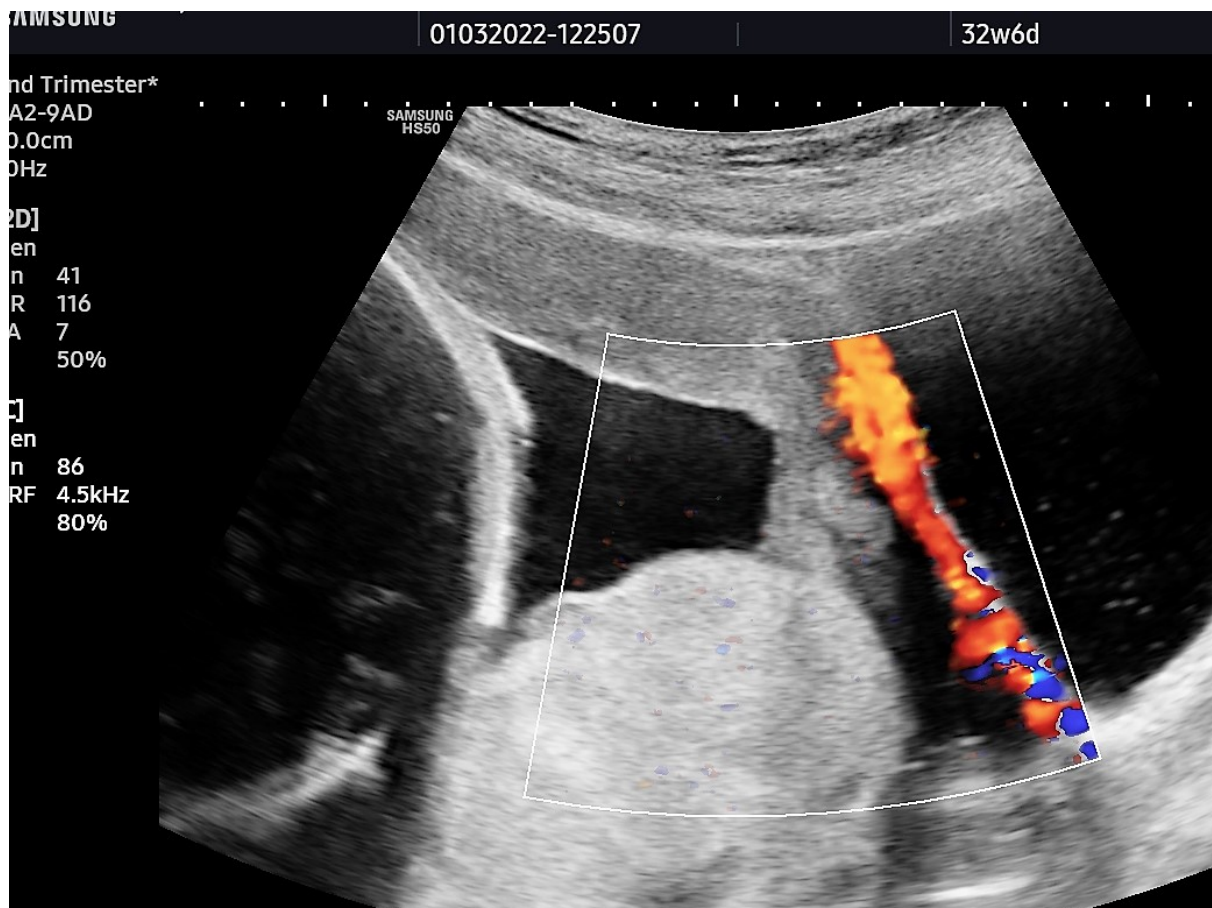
Ultrasound examination at admission: loss of clear zone, myometrial thinning, uterovascular hypervascularity and bridging vessels
